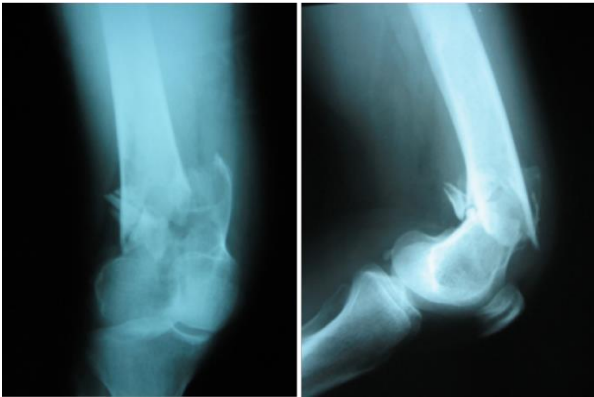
X-ray showing fracture of the distal femur occurring through the lesion
